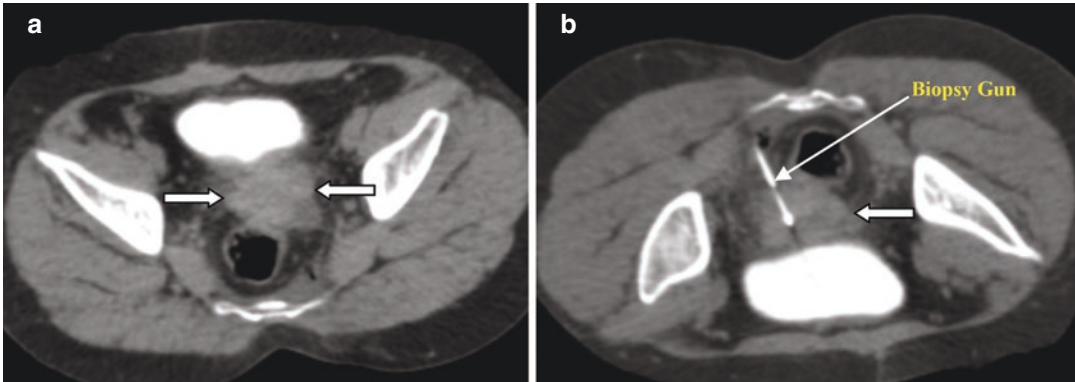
Post-operative (total hysterectomy and bilateral salpingo-oophorectomy) case of cervical cancer on follow-up. (a) Follow-up CT showing pelvic mass (thick horizontal arrows) posterior to the bladder and anterior to rectum (suspicious recurrent tumour). (b) Percutaneous
